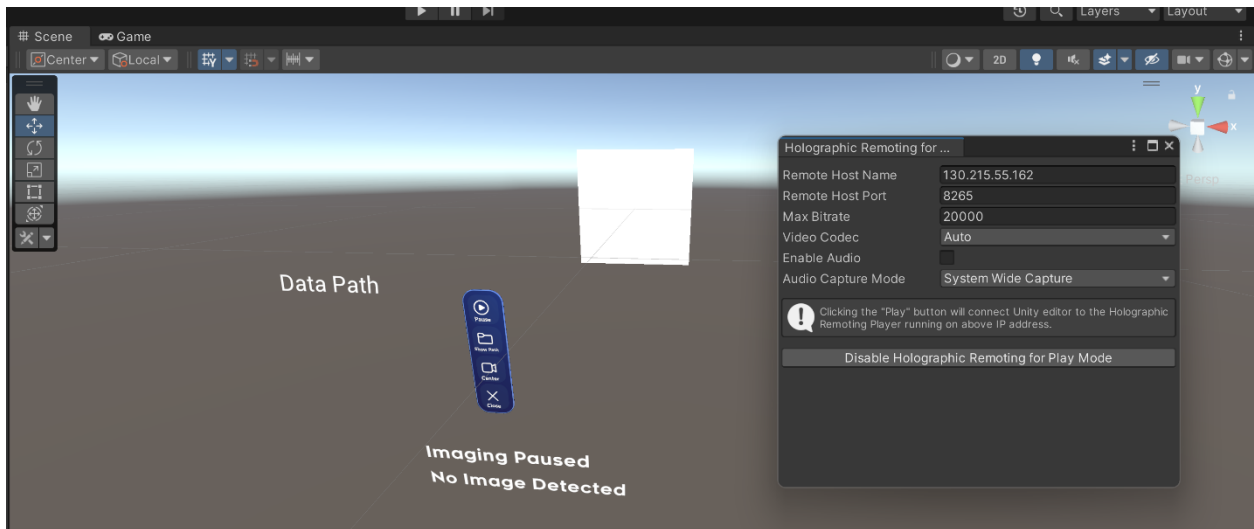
This screenshot from Unity shows our scene setup. To the right of the screen is the holographic remoting display. This enables Unity to stream the scene directly to the Hololens via TCP connection. In fact, if need be, it allows for changes to be made in real time so that the computer user can input and adjust components in the scene while the Hololens user is viewing said components. The white square in the middle of the screen is the plane in which ultrasound images are being sent via persistent data path. The blue rectangle on the left is the hand-initiated user interface with recenter, show data path, pause/play, and close options. A better image of this UI can be found in Figure 6.
